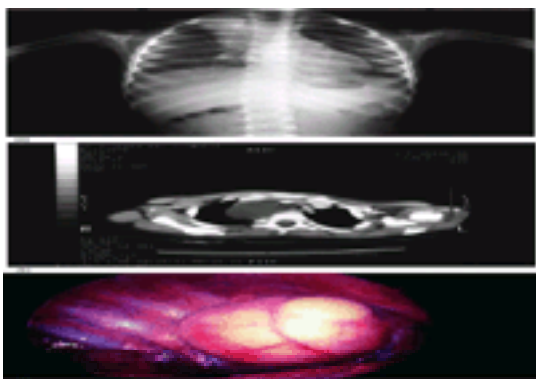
A 2-year-old female with a right-sided mediastinal mass on chest radiography (a) and CT scan (b). Thoracoscopic view of a cystic structure that was resected thoracoscopically and later confirmed to be an oesophageal duplication cyst (c).
